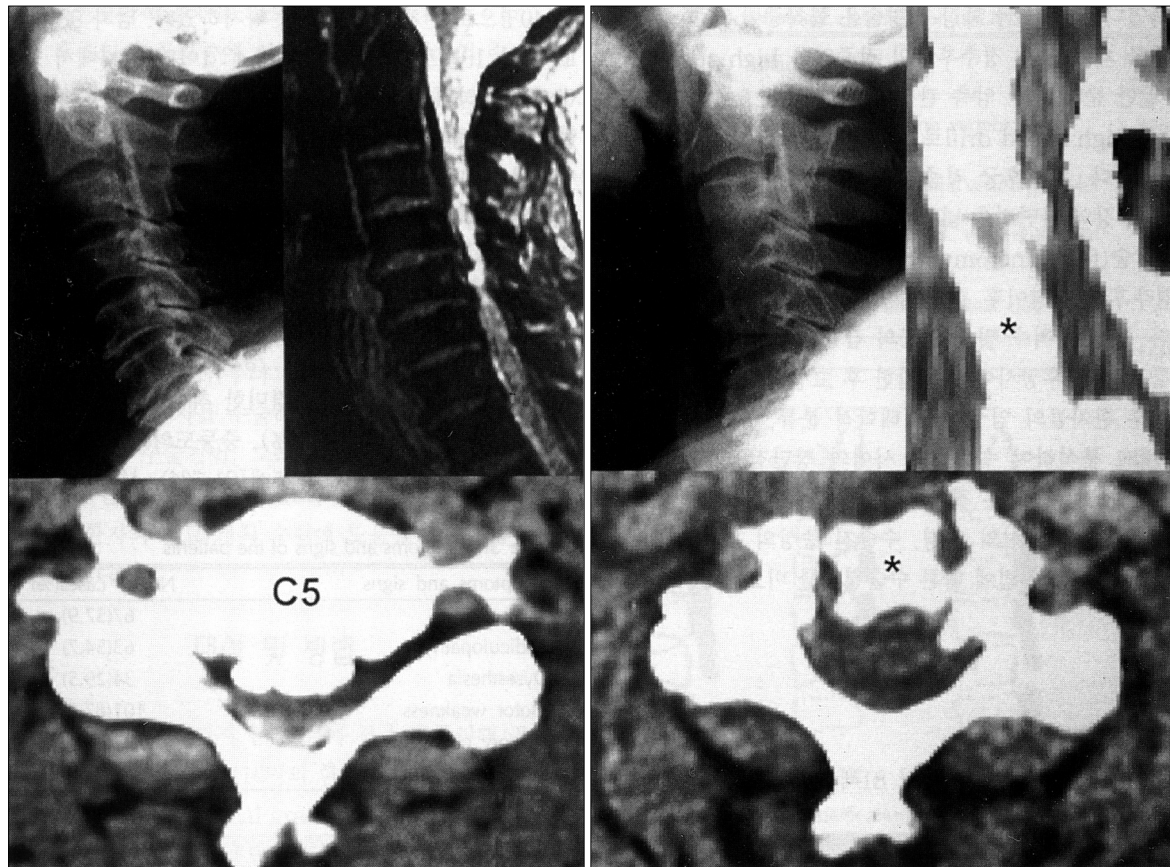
Pre-operative cervical spine lateral X-ray, CT scan and MRI demonstrate mixed type OPLL which compresses spinal cord. Post-operative cervical spine lateral X-ray and CT scan show spinal canal expansion after corpectomy and BOP graft with fusion.
